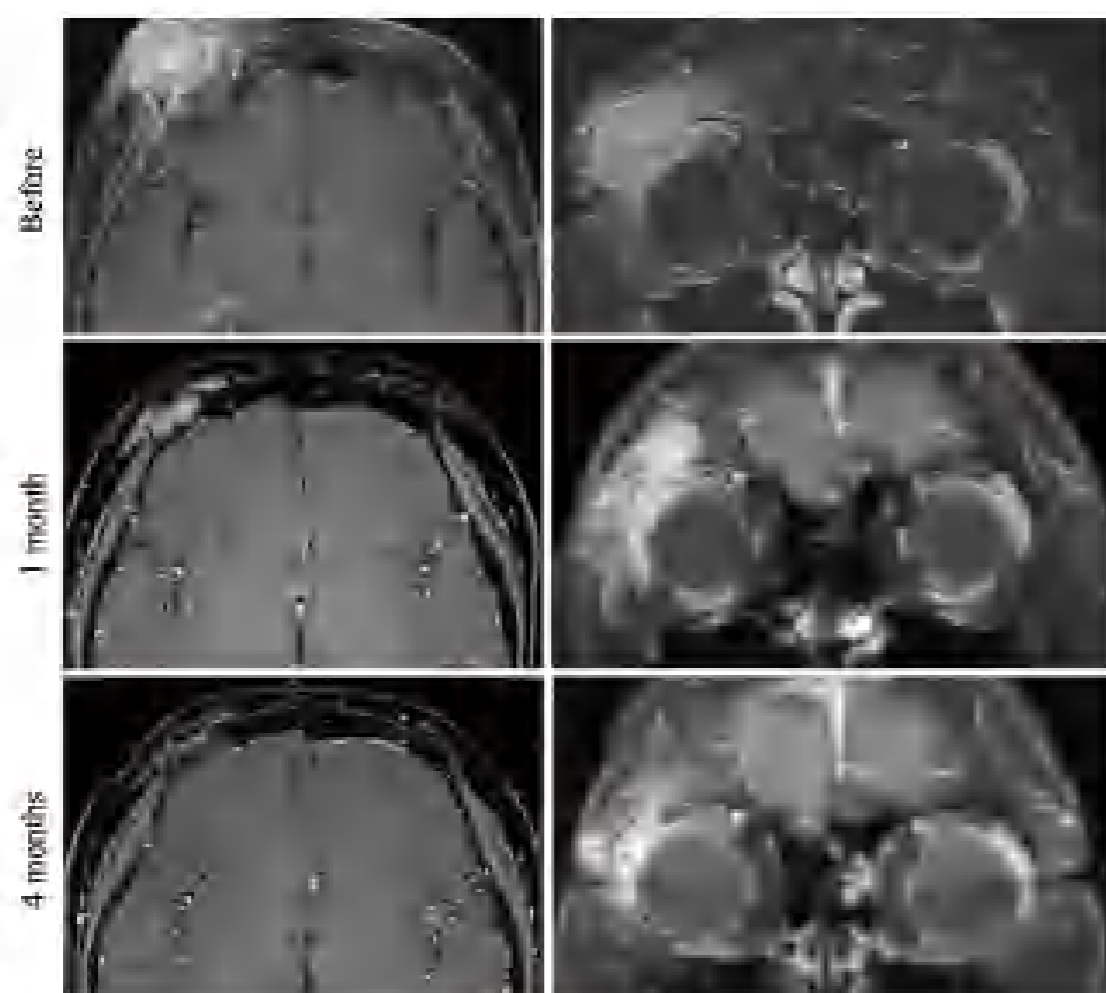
Post-contrast T1 sequence with fat suppression MR images before (top), 1 month (middle) and 4 months (bottom) after surgical resection
